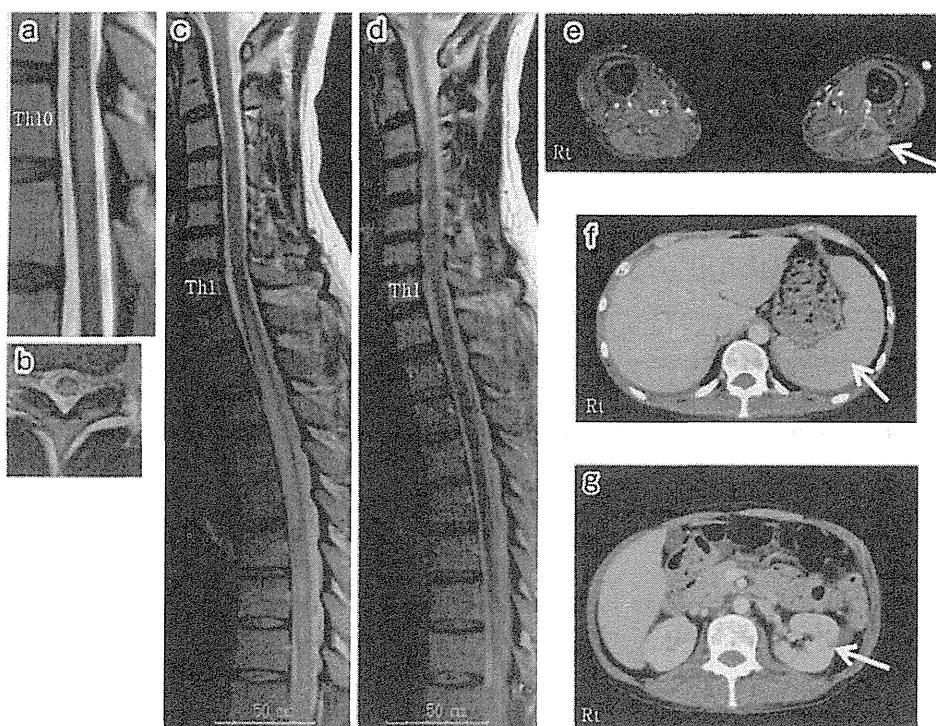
Magnetic resonance imaging (MRI) of the spine (1.5T T₂ weighted image: TR 2500 ms; TE 120 ms) and femoral muscles (1.5T short T₁ inversion recovery image, TR 3900 ms, TE 76 ms) and abdominal computed tomography (CT). (a) Sagittal MRI. Th 10-level axial MRI (b) at 2 months before admission to our hospital, (c) on the 53rd hospital day, before he was treated with R-CHOP therapy, and (d) on the 99th hospital day, when the 2nd round of R-CHOP therapy was performed and a T₂ weighted image showing a reduction in the high-intensity area. (e) MRI of the femoral muscles showing a high-intensity area in the left biceps femoris (arrow). Abdominal CT on the 23rd hospital day showing (f) splenomegaly (arrow) and (g) left renal lesion (arrow).
